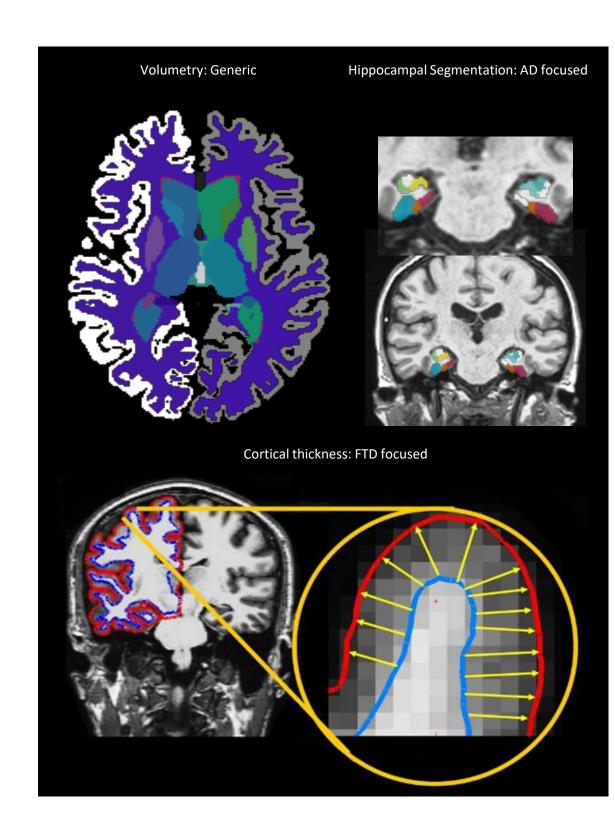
The model was trained with MRI-based metrics only: Volumetrics (including hippocampal subfields) and cortical thickness.
